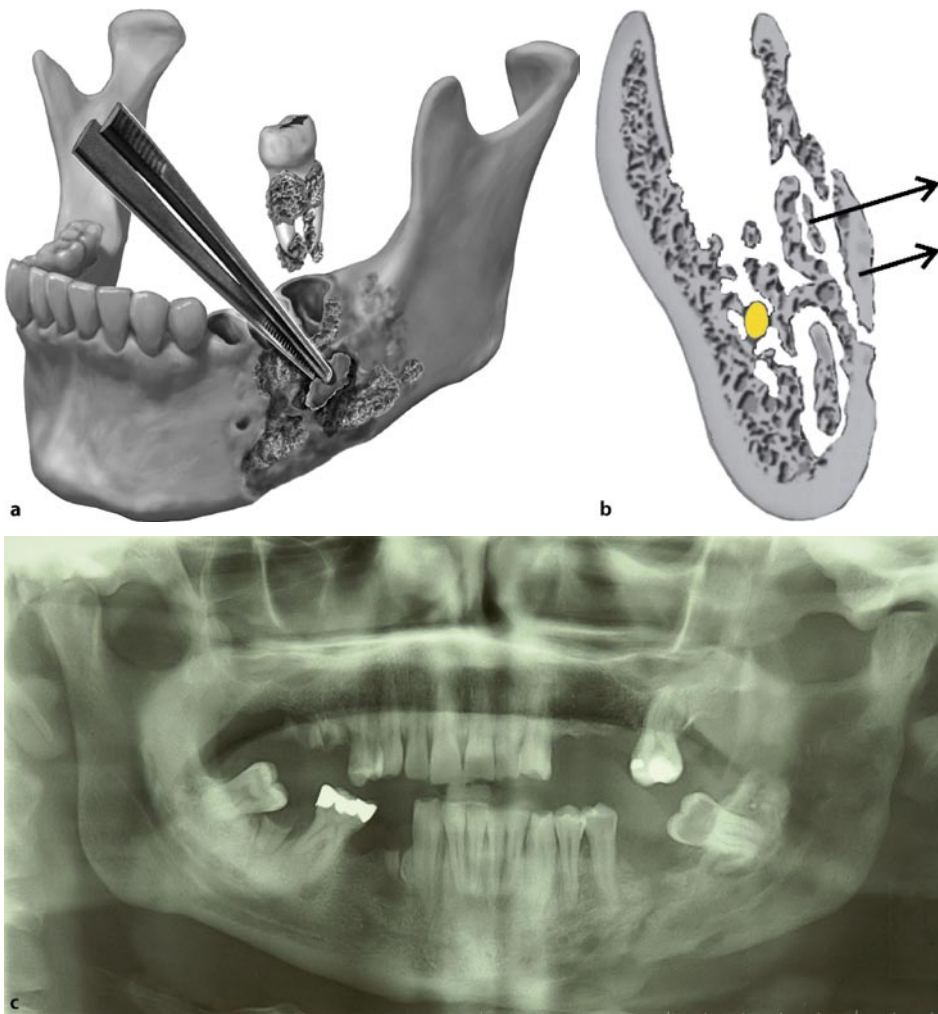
Removal of the odontogenic focus and the teeth in the affected region and removal of sequester (a,b). Patient with extensive secondary chronic osteomyelitis of the left mandible with formation of a large sequester at the base of the mandible in the premolar region and a pathological fracture: orthopantomography at initial presentation (c). d,e see next page. (Courtesy of N. Hardt)
